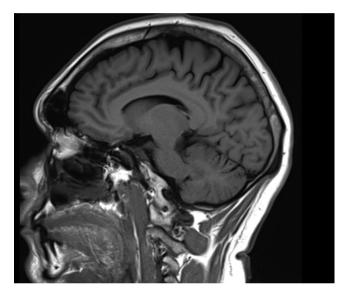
MRI post initial procedure which shows small localised soft-tissue lesion in the right fronto-parietal region (measuring up to 1.5 cm) with no extension to the underlying bone.
